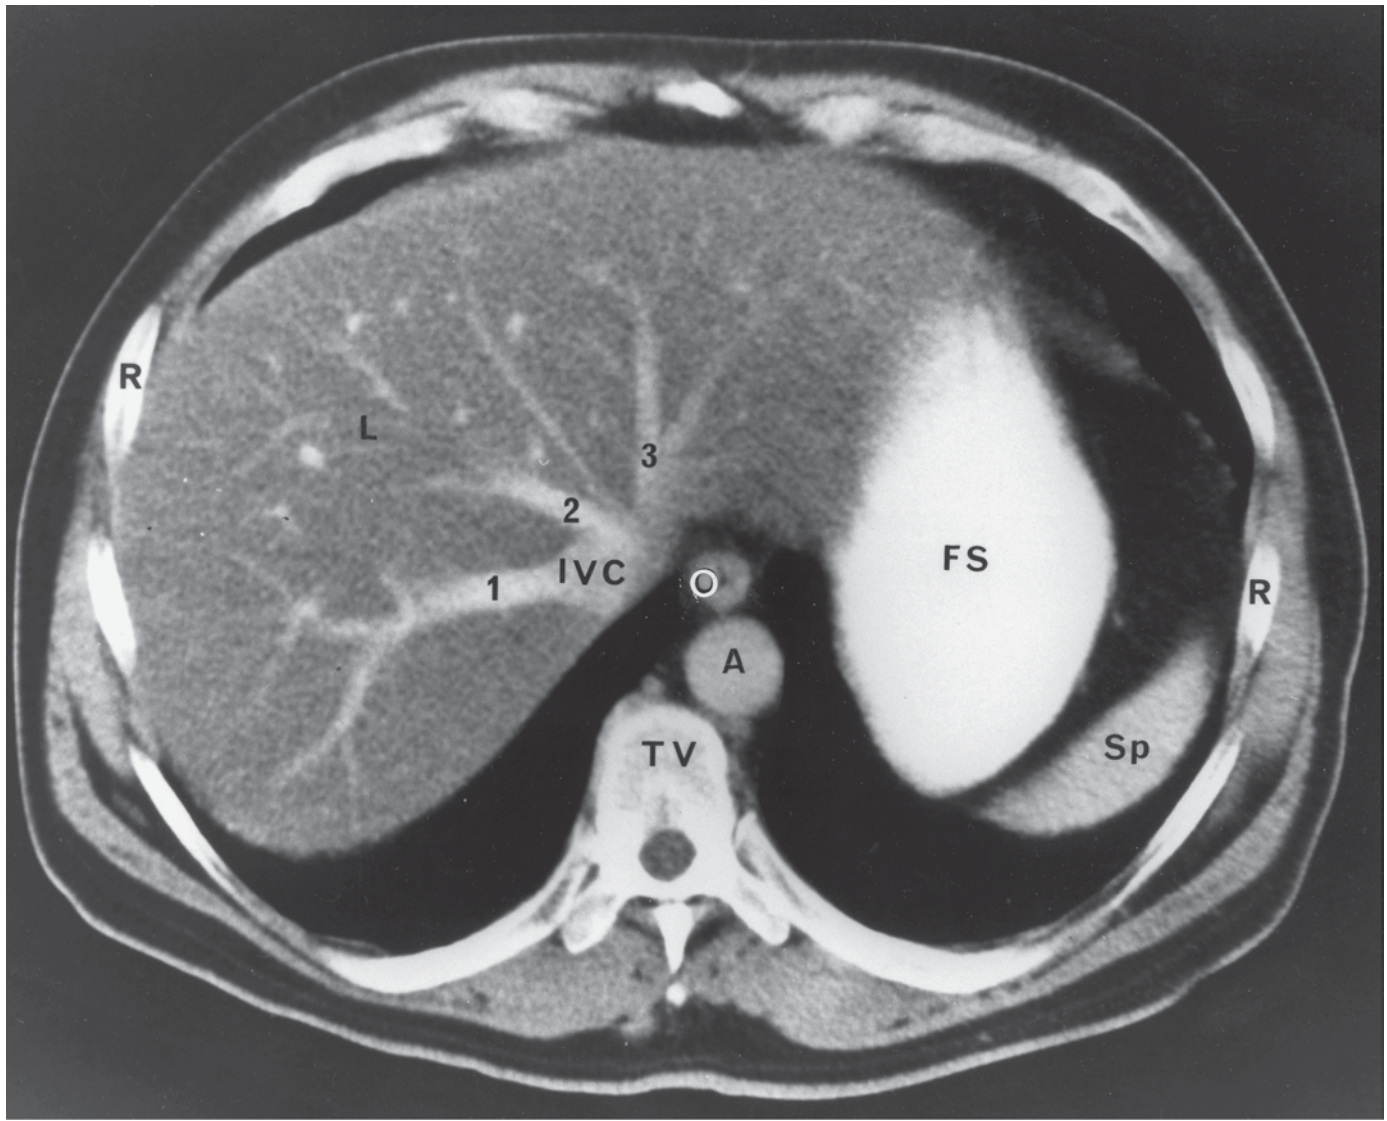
CT of the Upper Abdomen at Thoracic Level T10–T11
